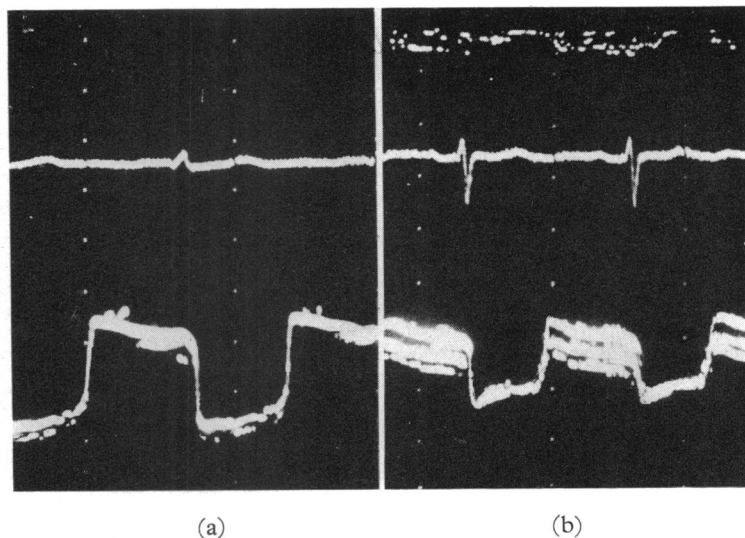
Echocardiograms from patients with lone mitral stenosis and sinus rhythm.* (a) *Thin mobile valve. The diastolic closure rate is under 10 mm./sec., but the amplitude of movement is nearly 3 cm.* (b) *Thick calcified and immobile valve. The diastolic closure rate is under 10 mm./sec. and the amplitude of movement is less than 2 cm. The echoes from the calcified valve are multiple.*
